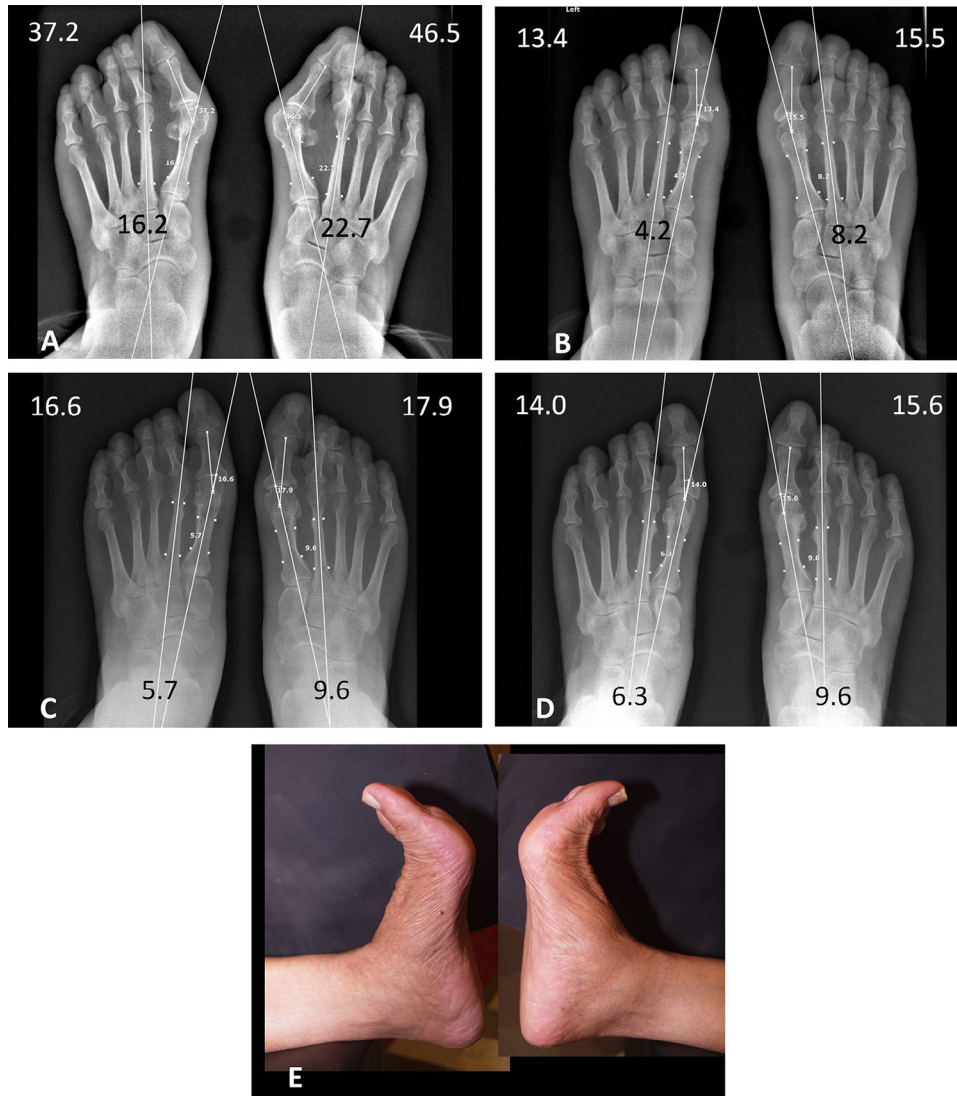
(A) Preoperative standing anteroposterior radiograph of a 68-year-old female's feet showing severe metatarsus primus varus deformity of the right foot with overlapping second clawed toe deformity and metatarsophalangeal joint dorsal subluxation. (B) Ten-day postoperative anteroposterior radiograph showing good realignment of the first metatarsal, hallux, sesamoids, metatarsophalangeal and metatarsocuneiform joints, and the right second toe, including its metatarsophalangeal joint. (C) Six-month postoperative standing anteroposterior radiograph showing slight reversion of hallux valgus and metatarsus primus varus deformities of both feet, especially intermetatarsal angle of right foot, which is abnormal at 9.6°. (D) Five-year postoperative standing anteroposterior radiograph showing no remarkable alignment changes of the first metatarsal, hallux, sesamoids, or second toe after 4.5 years. (E) Five-year photograph showing good active dorsiflexion movement.
